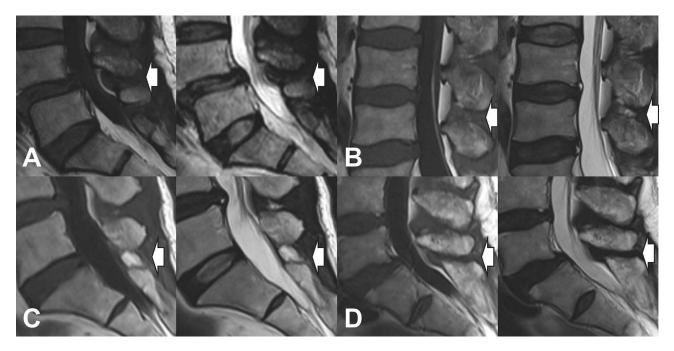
The components of the posterior ligament complex (white arrow) were classified into a 4-grade category according to the modified Fujiwara's criteria described by Kong. (A). Type 1 (low intensity on both T1- and T2-weighted images without hypertrophy of the spinous process); (B). Type 2 (low intensity on T1-weighted and high intensity on T2-weighted images); (C). Type 3 (high intensity on T1- and intermediate to high intensity on T2-weighted images); (D). Type 4 (low intensity on both T1- and T2-weighted images with hypertrophy of the spinous process); (D). Type 4 (low intensity on both T1- and T2-weighted images); (D).
